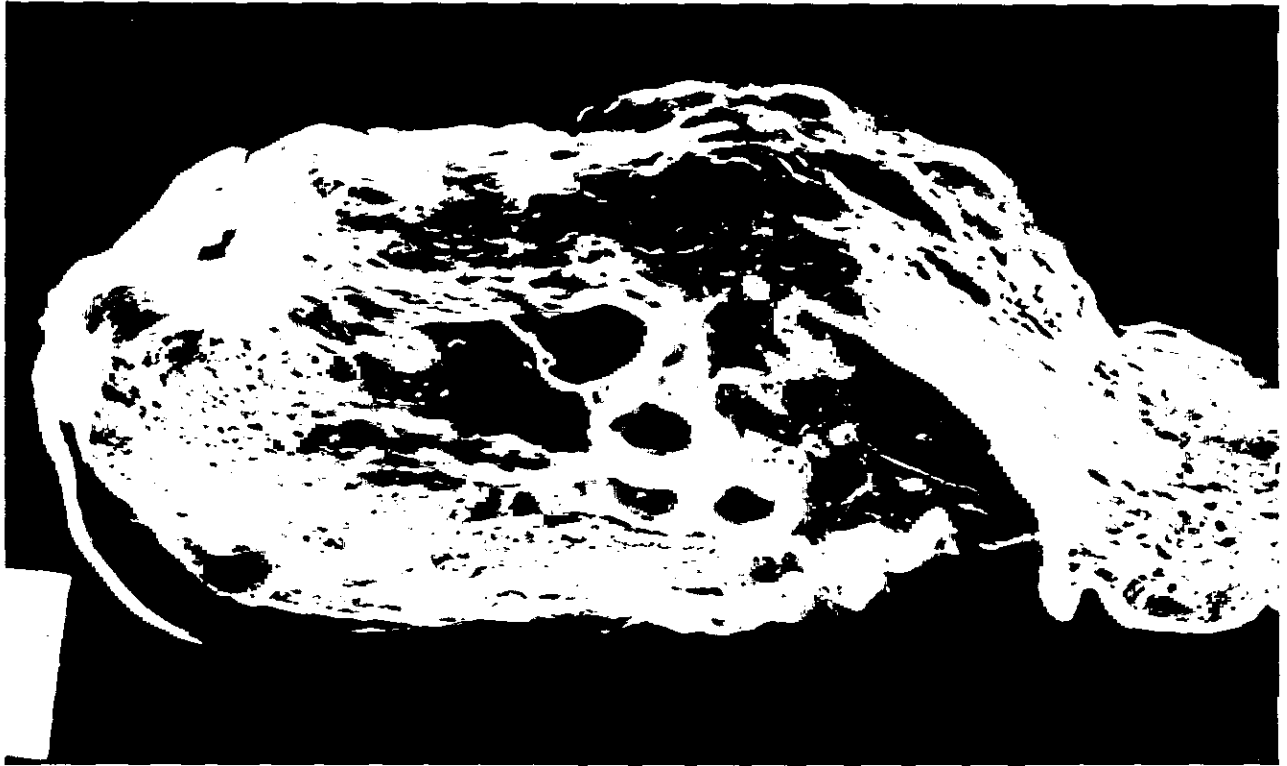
HRCT of autopsied lung after fixation at the level of middle lung field.
